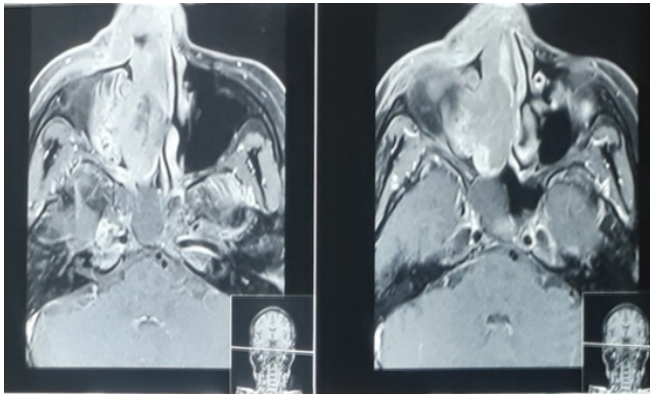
Post-contrast T1-weighted MRI of the nose and paranasal sinuses showing homogeneously enhancing mucosal thickening in the right nasal cavity extending from the choana to the nares, with erosion of the turbinates and medial wall.
